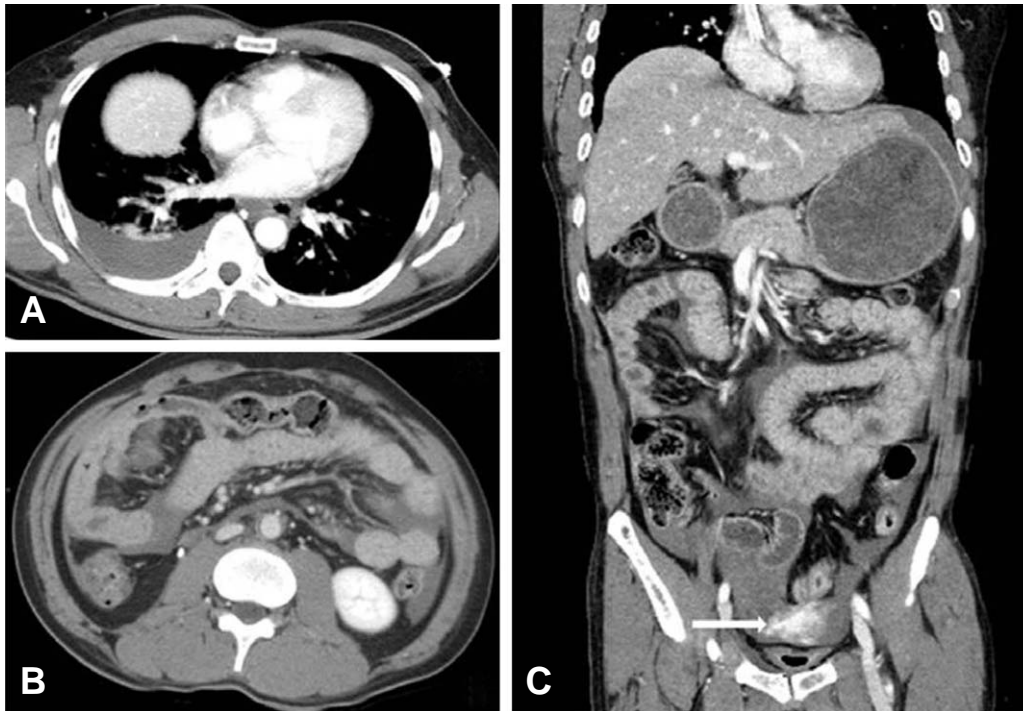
Preoperative CT showing right hemothorax (A), hemoperitoneum (B), the arrow is extravasation of the contrast (C).
